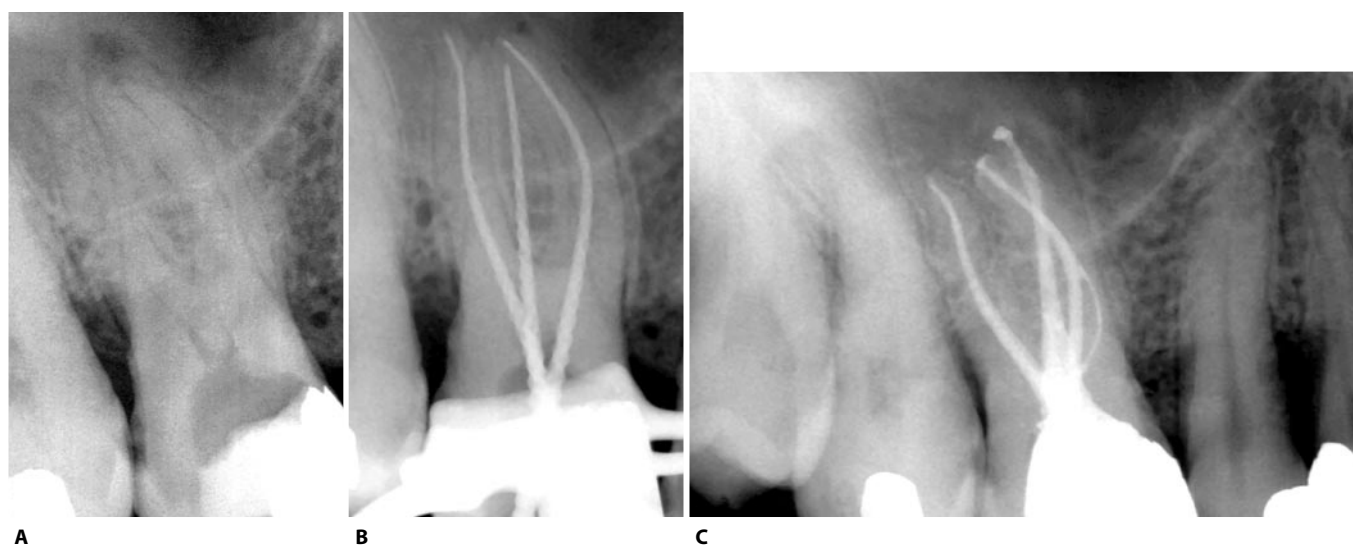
A. Endodontic treatment of an upper right first molar with long (24 mm) and curved roots. B. Thermafil verifier. The mesial root appears to have only one canal. C. The post operative radiograph however shows the presence of a loop that was cleaned and filled thanks to an effective irrigation sequence and the flowability of the Thermafil gutta-percha.
